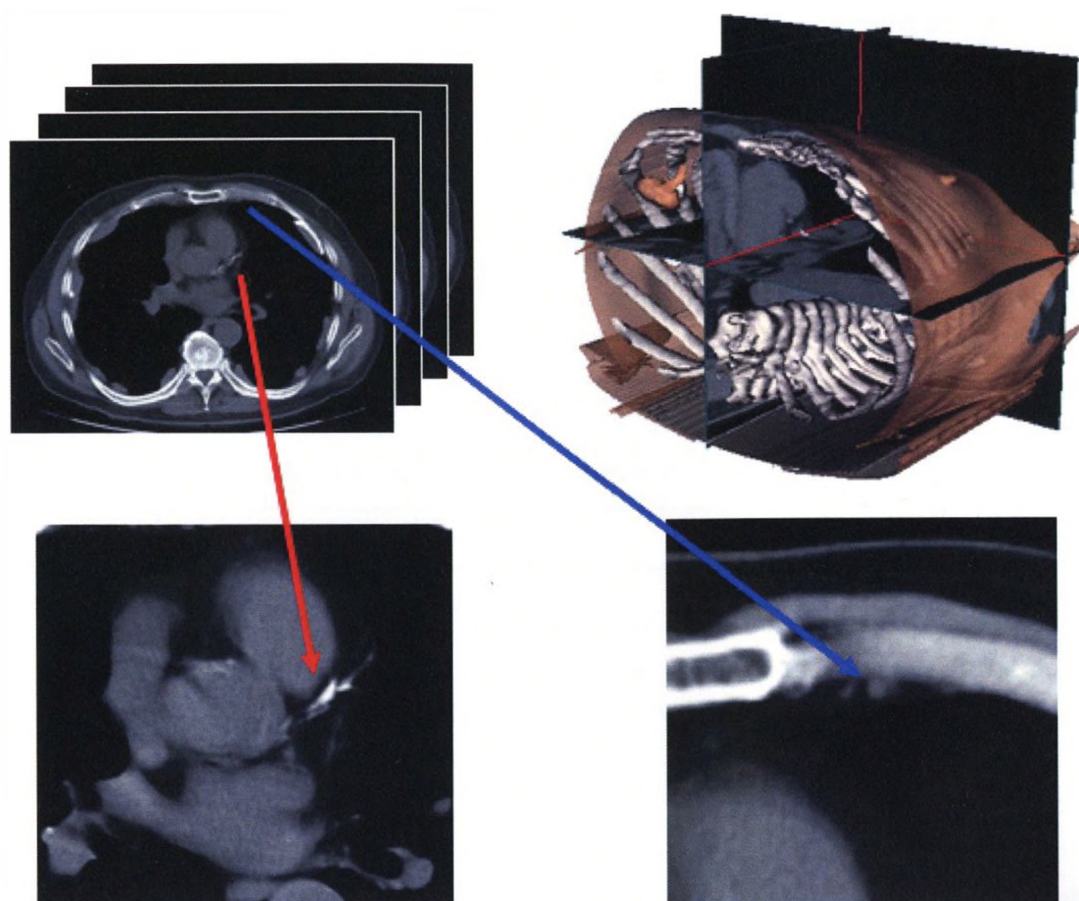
3D Pre-operative CT imaging. *Top*: Multi-slice CT images are converted into an interactive 3D tri-plane volume with segmented ribs and skin. *Bottom*: Focusing in on the heart reveals the LAD blockage site (*red arrow*); and, a trained eye can localize the LITA (*blue arrow*) used for bypass.
